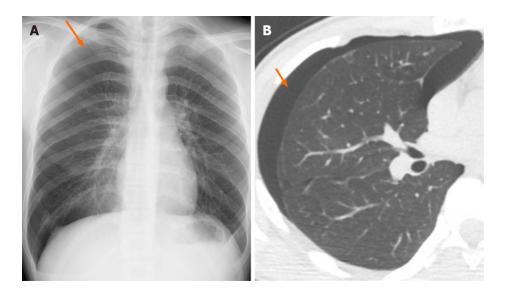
Chest X-ray and computed tomography scan revealed right-sided pneumothorax. A: Chest X ray in anterior-posterior view; B: Computed tomography scan in axial plane.
